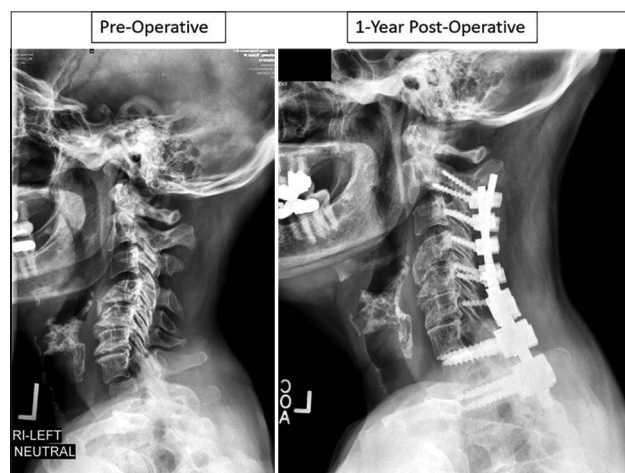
Lateral cervical radiographs of pre- and 1-year postoperative for a case example of a patient who achieved a good overall outcome as defined by Model 4. This patient is a 52-year-old female with a body mass index of 24.3 kg/m² who underwent cervical deformity corrective surgery from C2 to T2 with no pedicle subtraction osteotomy performed. At baseline, cSVA was 2.7 mm, TS-CL was 15.6°, and horizontal gaze was 2.9°. 1-year postoperatively, cSVA was 18.9 mm, TS-CL was 31.3°, and horizontal gaze was 8.9°. This patient had a baseline mJOA score of 12 and postoperative score of 13, thus slightly improving in mJOA but not reaching minimum clinically important difference. cSVA - Cervical sagittal vertical axis
